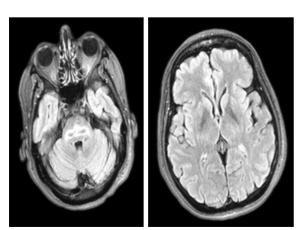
T2-FLAIR axial images display symmetrical hyperintensity in the chronic phase due to demyelination in the central pons, bilateral basal ganglia, and thalamus. FLAIR: Fluid-attenuated inversion recovery.
